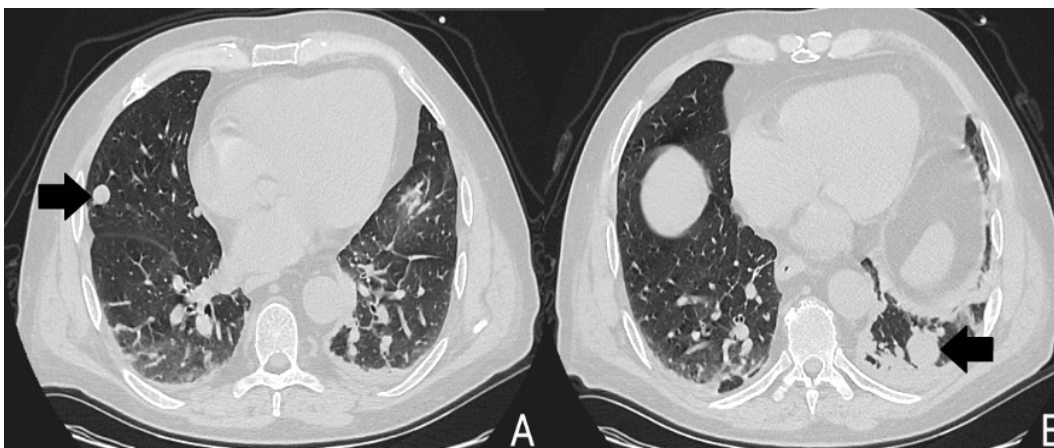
Axial CT scan of the chest displaying bilateral pulmonary nodules (indicated by black arrows in panels A and B), highly indicative of metastatic lesions, along with a minor left-sided pleural effusion.
